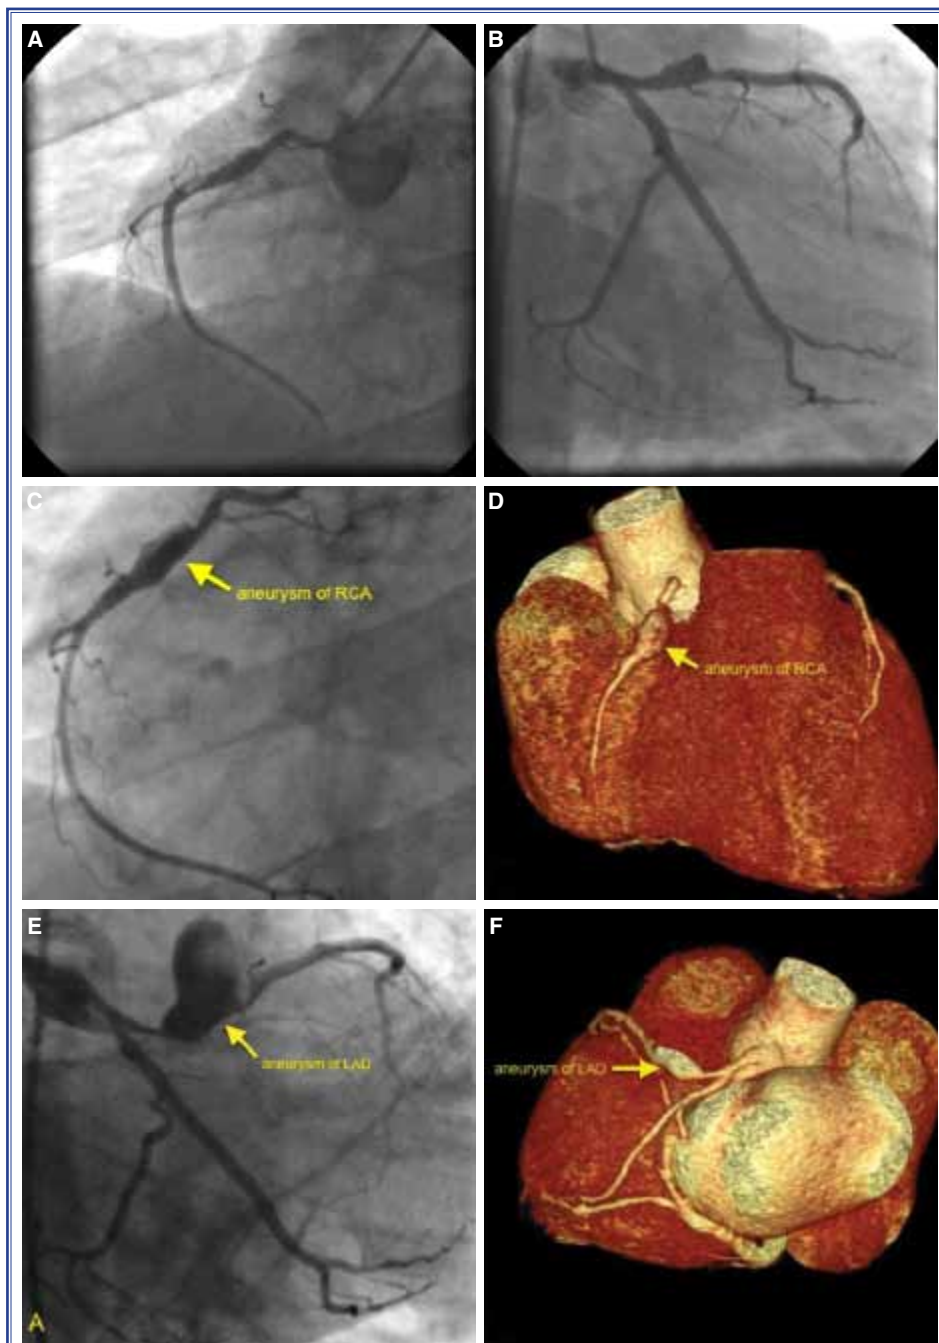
(A) Coronary angiography showed a fresh thrombus in the proximal segment of right coronary artery. (B) Coronary angiography showed an aneurysm of 12 mm diameter of left anterior descending artery at the proximal segment with a hemodynamically significant lesion following the aneurysm. (C) Control coronary angiography showed dissolution of the thrombus buta new aneurysmal dilatation of right coronary artery, (D) Coronary multidetector computed tomography view. (E) Control coronary angiography showed gigantic transformation of the aneurysm of left anterior descending, (F) Coronary multidetector computed tomography view.
